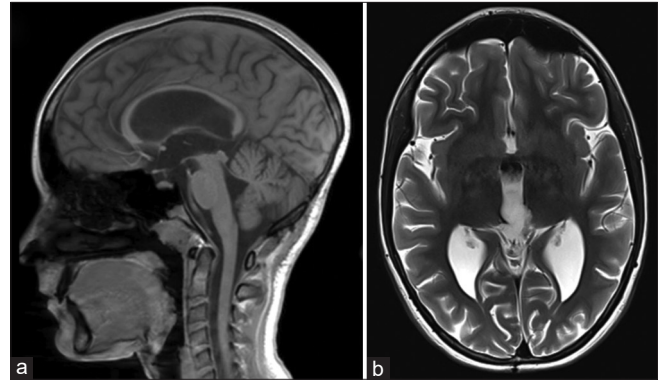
Postoperative magnetic resonance imaging (MRI). T1-weighted mid-sagittal (a) and T2-weighted axial (b) MRI scans show no signs of residual/recurrent tumor mass or hydrocephalus.
